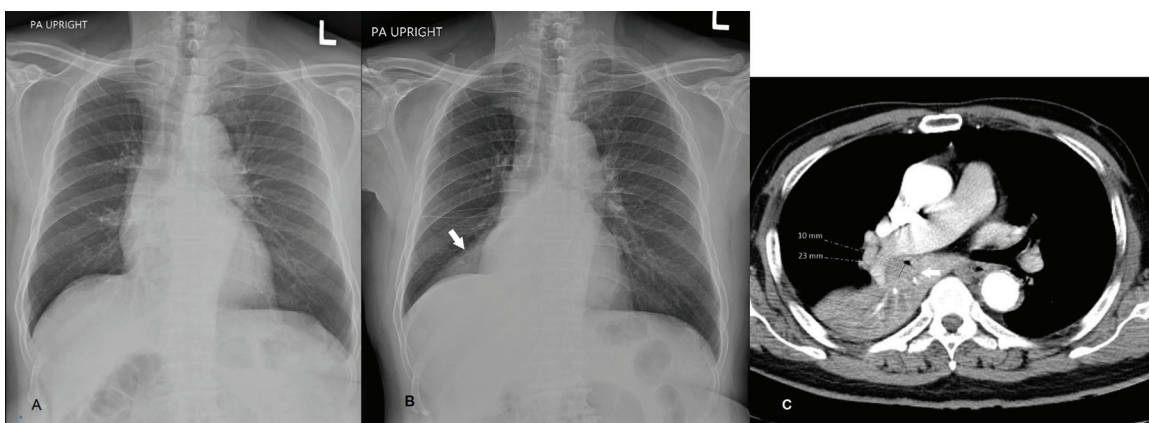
A 67-year-old man with intermittent cough for 1 year. (A) His first chest radiograph revealed normal even he experienced the symptom. (B) He developed non-massive hemoptysis 300 days after the first visit. His chest radiograph showed triangular shape opacity at the medial aspect of the right lower lobe with slightly decreased right lung volume. These findings could represent right lower lobe atelectasis, but there is no direct observation of any lung mass in this radiograph. (C) Further chest CT scan revealed an endobronchial mass in the right lower lobe bronchus, measuring about 10×23 mm, causing right lower lobe atelectasis. The tumor was confirmed to be a squamous cell carcinoma.
